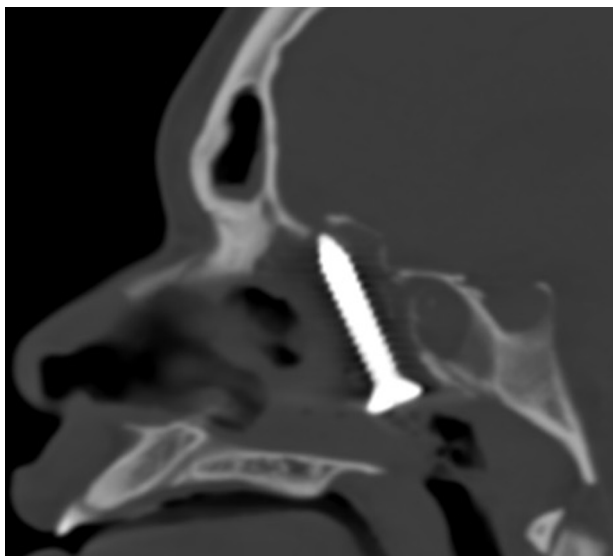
Initial non-contrast CT sinus sagittal view demonstrating size and position of intranasal foreign body, identifiable as a radiopaque screw. CT indicates computed tomography.
